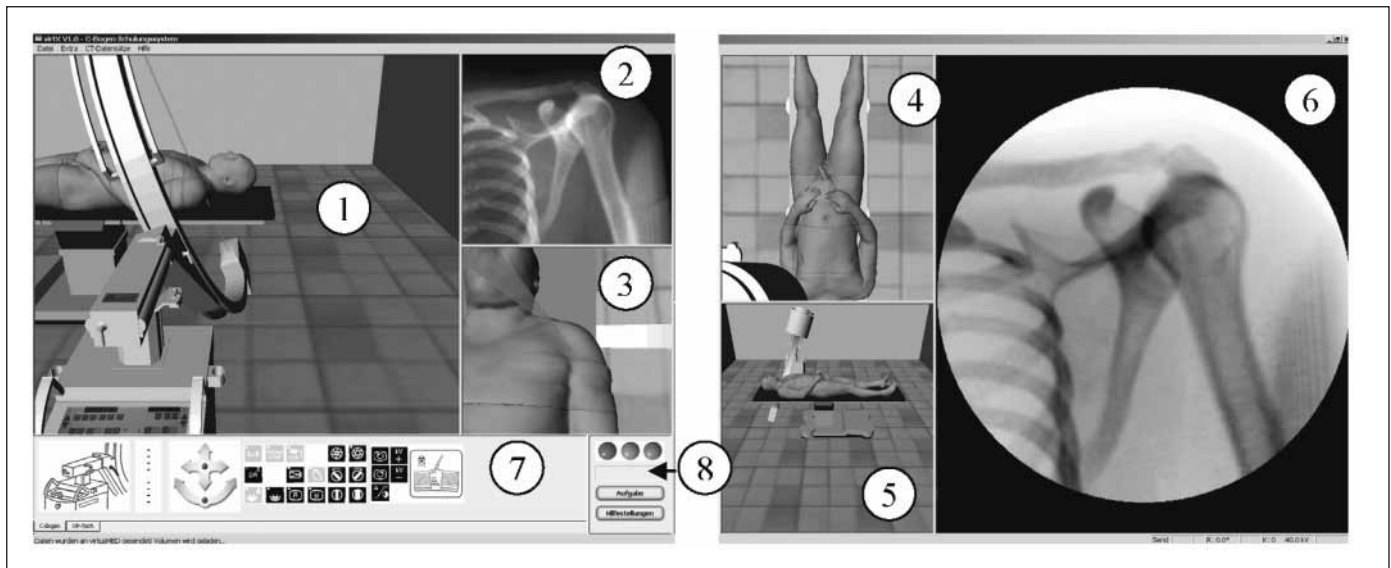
User interfaces of the virtX CBT presented on two monitors. 1) Virtual operation theater and C-arm from the position of the C-arm operator. 2) Virtual radiograph (fluoroscopy mode). 3) View from the image intensifier onto the patient including the conducting laser
